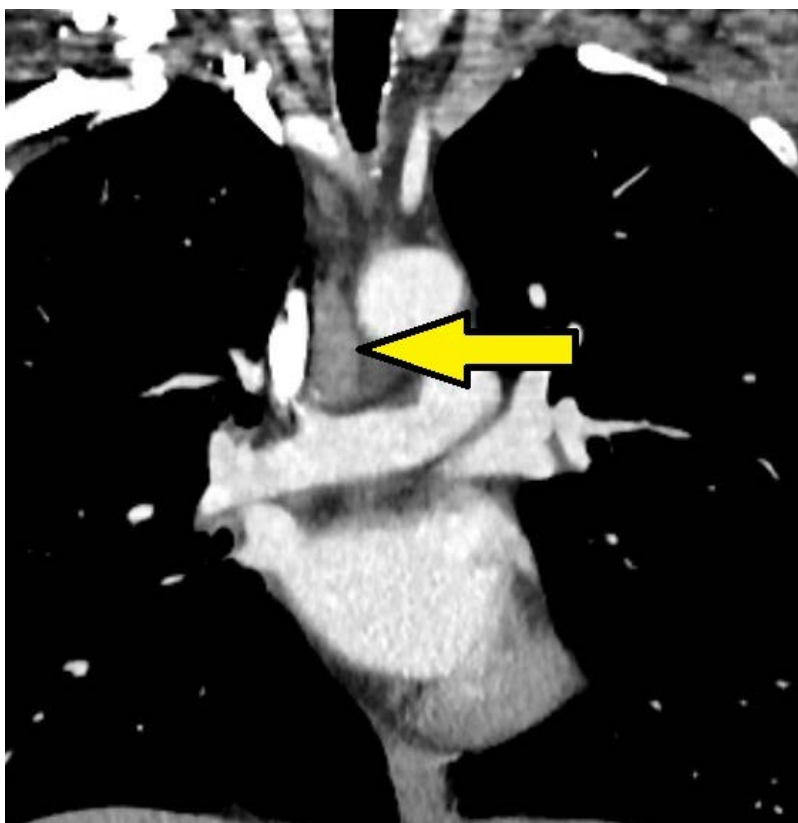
Chest multi-detector computed tomography: enlarged right lower paratracheal (station 4R) lymph node (coronal section).
